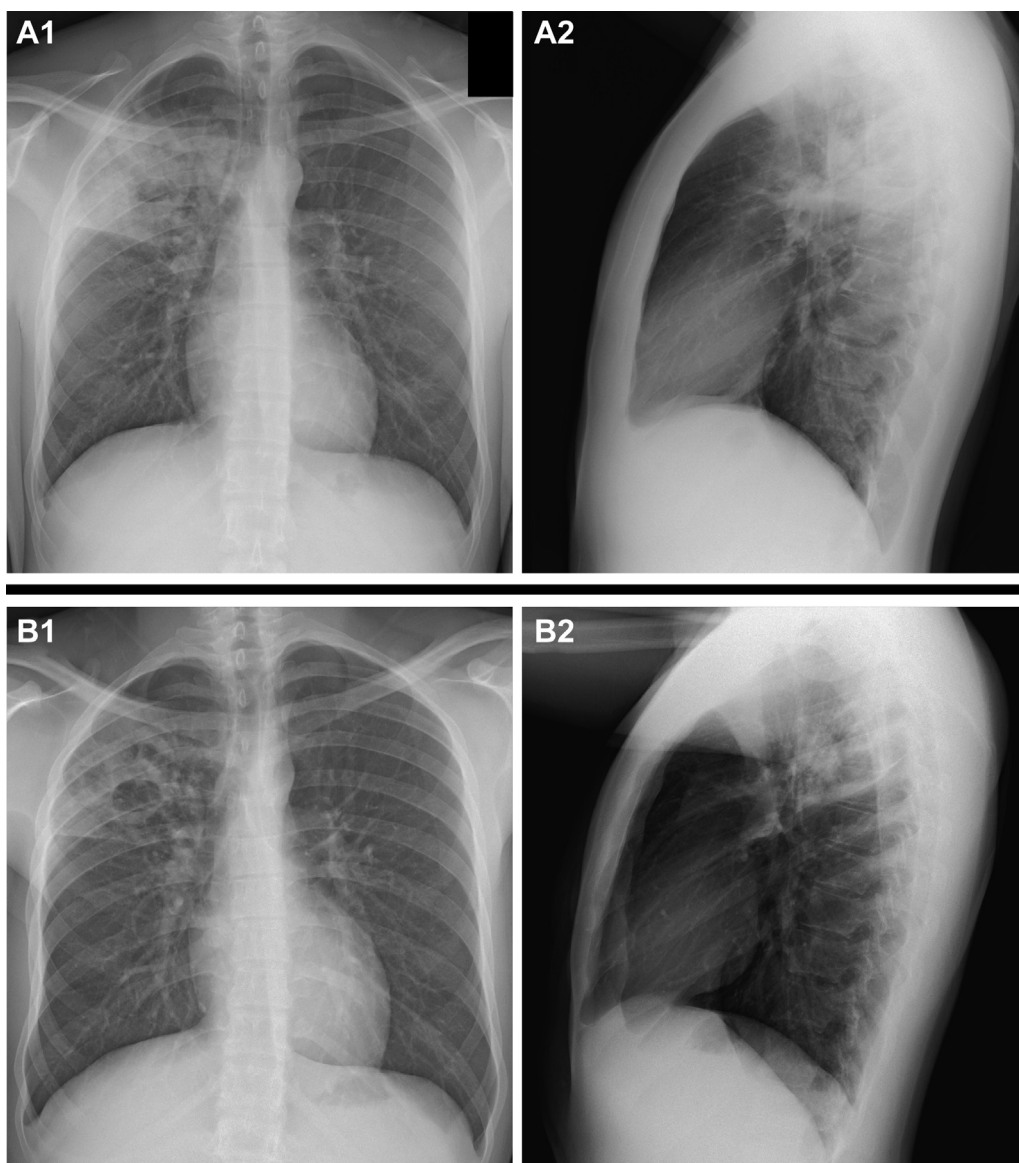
A1-A2, Anteroposterior and lateral chest radiographs on discharge. B1-B2, AP and lateral chest radiographs four days after discharge.
